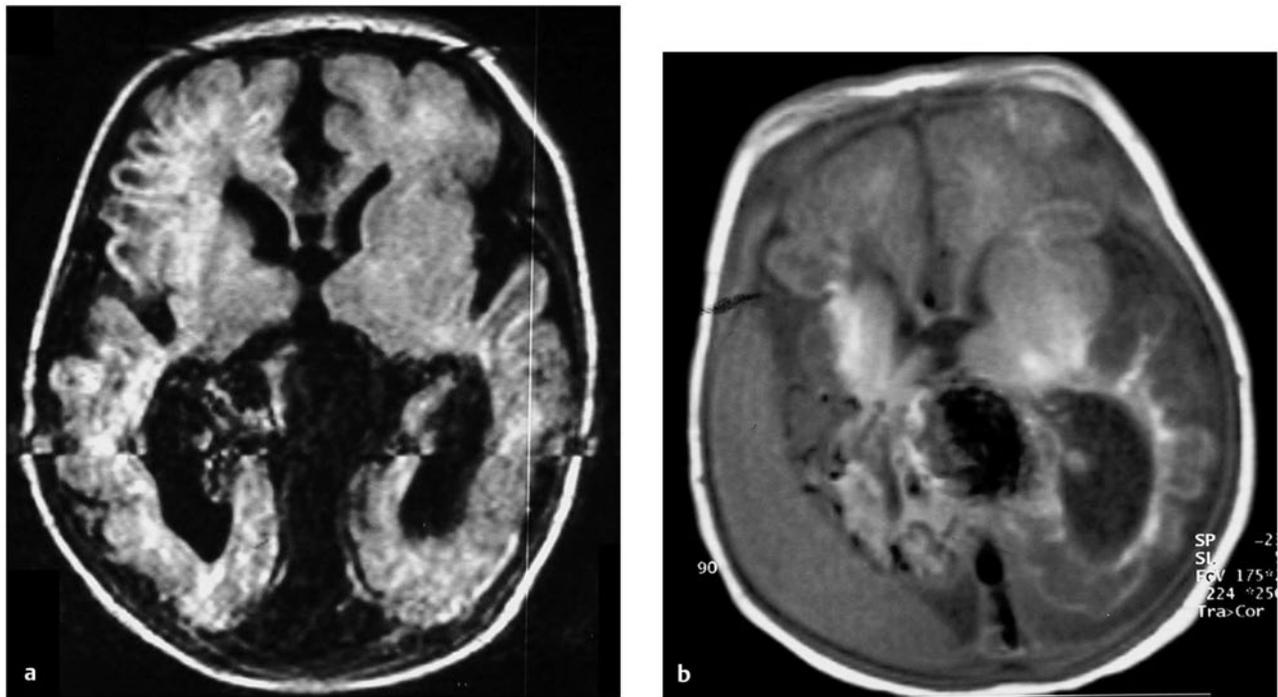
This male patient presented with severe congestive heart failure (CHF) at birth. (a) FLAIR (fluid-attenuated inversion recovery) magnetic resonance (MR) imaging at 1 day old demonstrates severe brain tissue loss and midline vascular malformation with a dilated vein of Galen. The patient underwent transarterial and transvenous embolization at 2 days and at 12 days old at an outside institution with technical success in partial obliteration of the vein of Galen aneurysmal malformation, although treatment was not indicated because of significant brain damage. (b) T1-weighted MR imaging at 25 days old demonstrates the progression of brain atrophy and a subdural fluid collection. *Arrow* indicates coils in the draining vein. At 18-month follow-up, the patient had no CHF but was on tracheostomy and tube feeding with spastic quadriplegia. The patient underwent embolization at this time with complete occlusion of the malformation and relief of apparent headaches.
